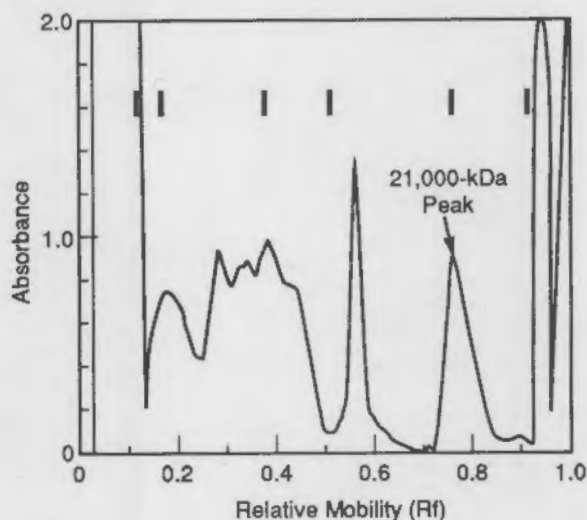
SDS Polyacrylamide Gel Electrophoresis of Extract of CT-24 Bladder Cancer Cells. Material in 21,000-kDa band was reactive with antibody specific for *ras* oncogene family of proteins by Western blot analysis. Large bars represent migration position of protein standards used for molecular weight estimation.
